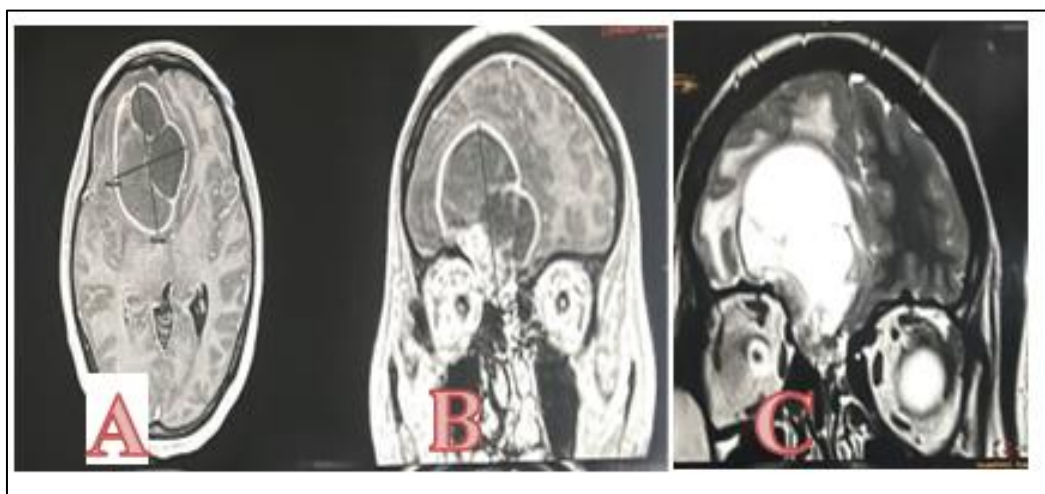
Cerebral Magnetic resonance imaging (T1) axial(A) and coronal(B) with contrast showing the cystic wall with intense enhancement and the cystic zone without enhancement. Coronal (T2) magnetic resonance imaging (C) showing the isointense cystic wall and the homogeneous hyperintense appearance of the cystic zone. Obvious vasogenic edema surrounded the mass
